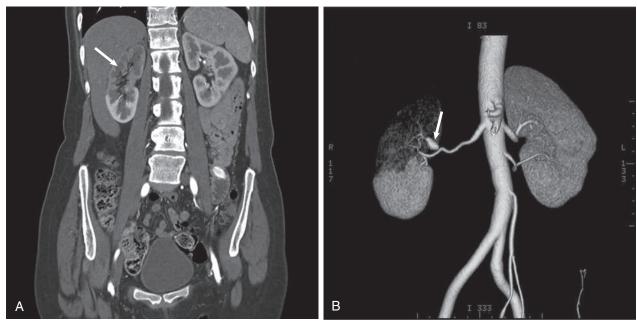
Computed tomography angiogram of renal artery aneurysm with area of renal infarction in right kidney. (A) Coronal image demonstrates area of intact tissue with no blood perfusion within the kidney parenchyma (white arrow). (B) Reconstructed view with vascular aneurysm (arrow) and minimal flow in the distribution beyond this segment, consistent with near-total occlusion. This patient presented with accelerated renovascular hypertension treated primarily with renin-angiotensin system (RAS) blockade.
